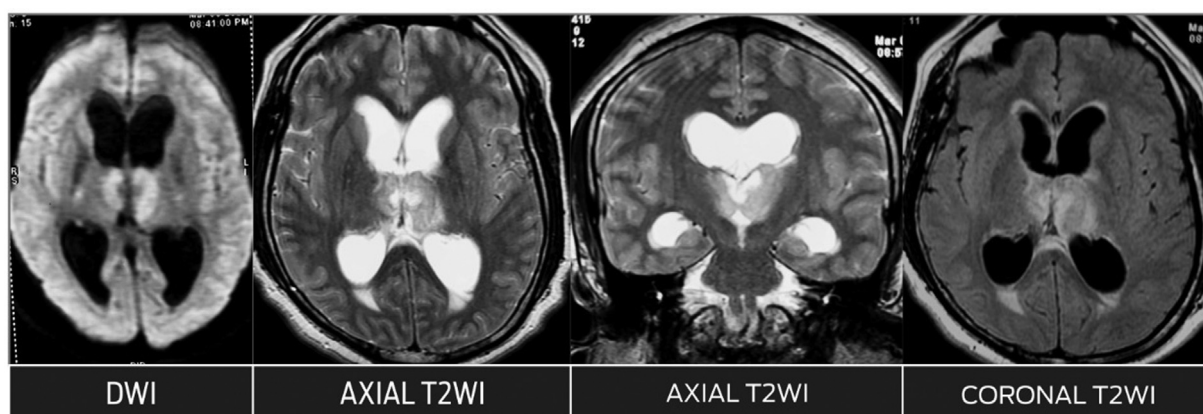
Pretreatment MRI shows mass lesion in the region of the third ventricle with involvement of bilateral thalami, with perilesional edema in the thalami showing restricted diffusion with diffuse T2, fluid-attenuated inversion recovery (FLAIR) hyperintensity, and postcontrast enhancement and dilatation of the lateral ventricles with periventricular hyperintensity.
